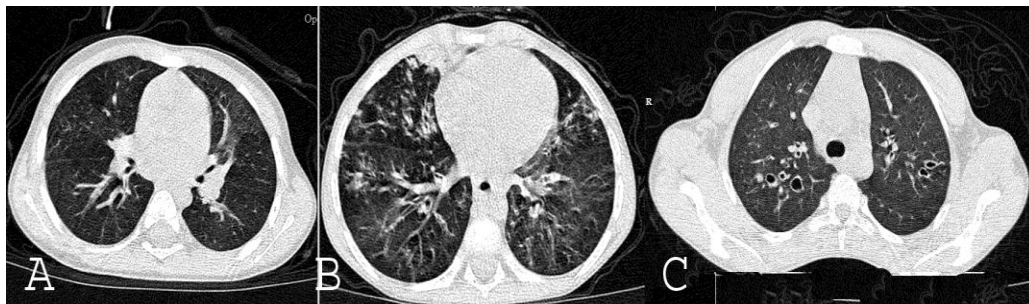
Low dose CT images (KVp=90, mAs=30 & 50) in three children with diagnostic patterns. A) Image of a 3 month-old boy with HRAD presenting as generalized geographic pattern of air trapping. B) Image of 5 year old boy with HRAD having geographic pattern and tree in bud. C) Bilateral Bronchiectasis in 16 yearold boy with Cystic Fibrosis.
